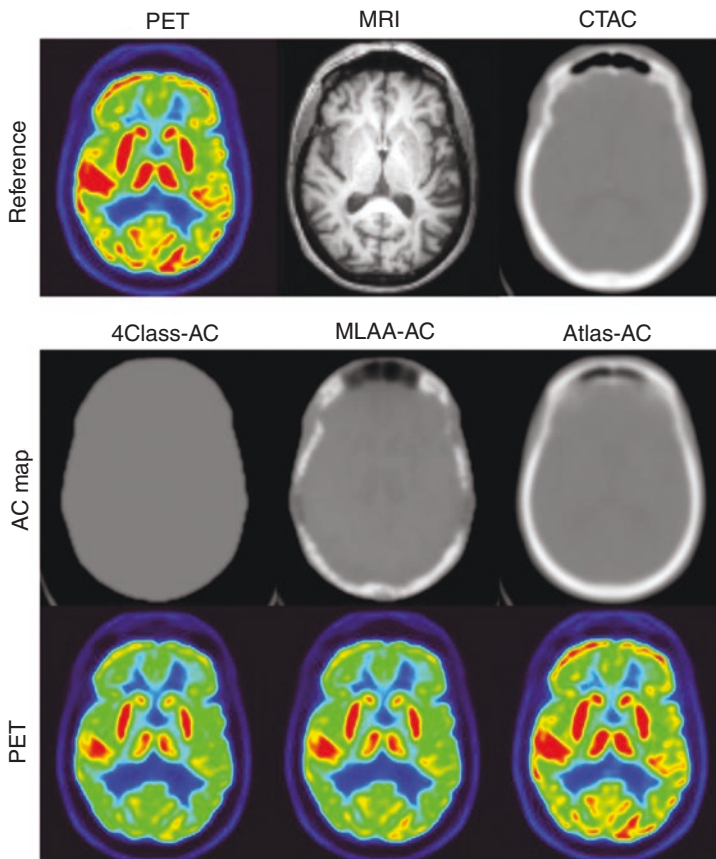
Representative clinical FDG brain PET study showing from left to right: (top row) PET, MR, and CT images used as reference for evaluation, (middle row) attenuation maps derived using different attenuation correction approaches including segmented MRI, Atlas-guided, and maximum likelihood reconstruction of attenuation and activity (MLAA) technique, (bottom row) corresponding reconstructed PET images. Note the limitations of segmented MRI-based approach which ignores the skull and air cavities. The Atlas-based approach better matches the patient's CT image, clearly outperforming the MLAA algorithm
